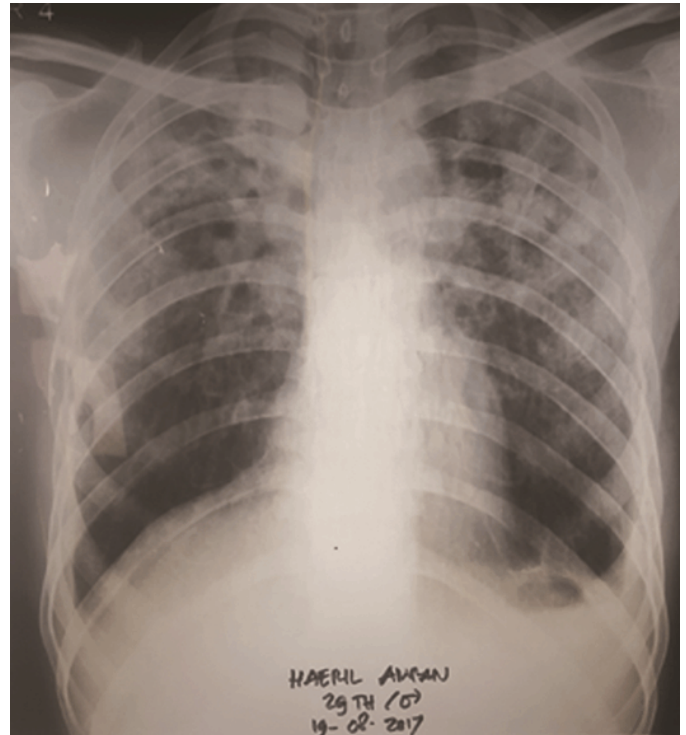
Chest X-Ray showed increased opacity on both lungs with fibrotic line which retracts both hillus and diaphragm, referred to old and active lung Tuberculosis with wide lesion.
